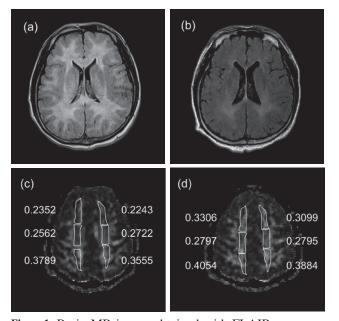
Brain MR image obtained with FLAIR sequence before HBOT (a) and six weeks after HBOT (b) shows resolution of diffuse white matter change. The brain diffusion tensor MRI obtained before (c) and after (d) hyperbaric oxygen therapy. (b) The values of fractional anisotropy of the six regions of interest on the bilateral centrum semiovale are higher than their correspondents in (c).
